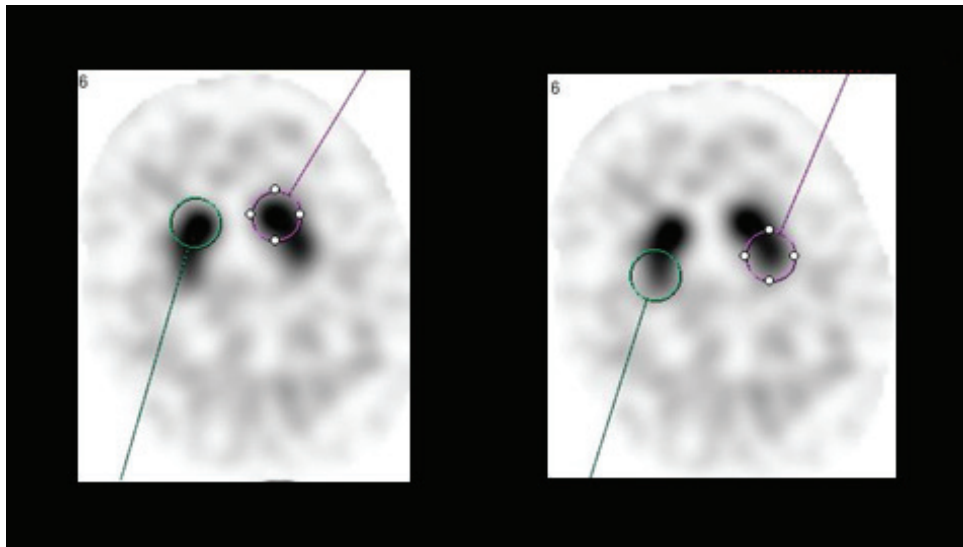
SUV_{max} and SUV_{peak} of caudate and putamen on both sides in the normal patient showing caudate SUV_{max} of 11.37 and putaminal SUV_{max} of 9.84 on the left side, reflecting the left sided putamen to caudate ratio of 0.93.
